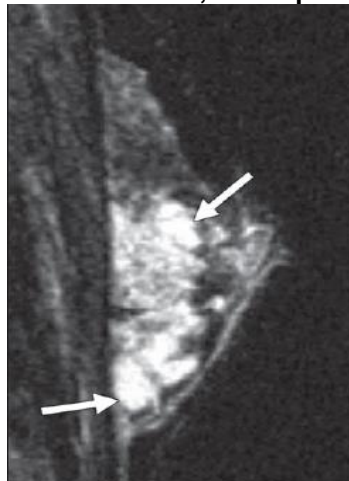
Fat-saturated, sagittal, T2-weighted MR image of left breast shows areas of hyperintense T2 signal within mass (arrows)
